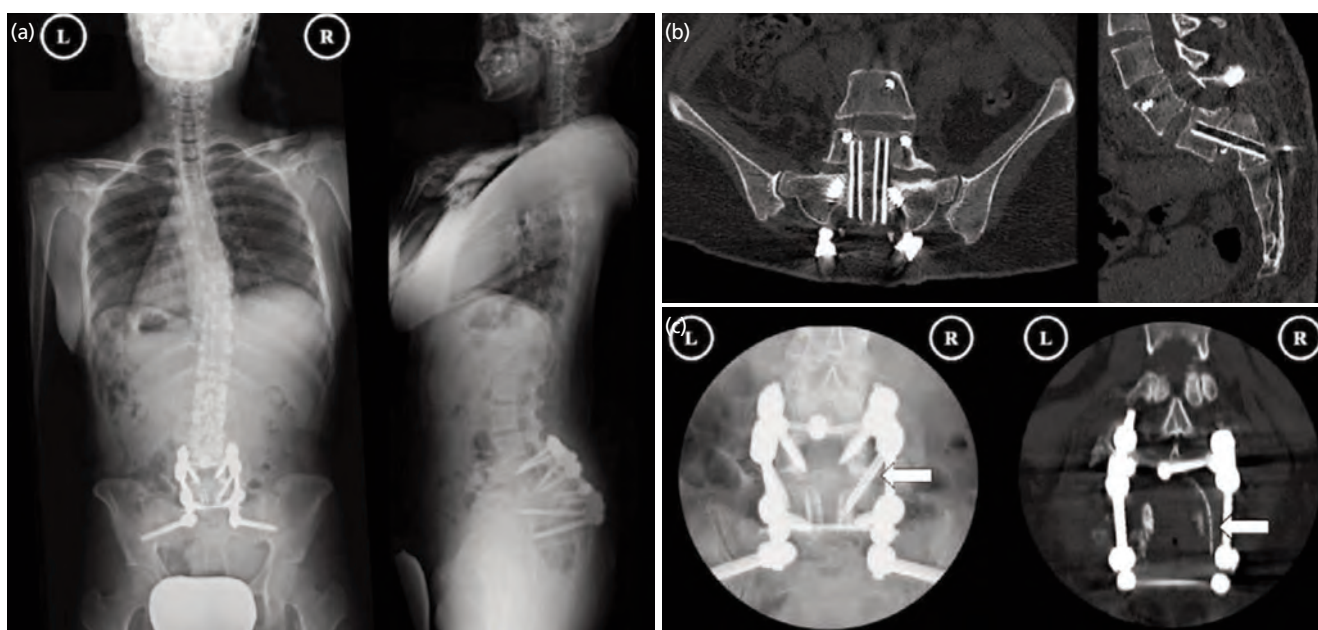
Post-operative radiographic and CT images. (a) Post-operative whole spine radiographs after posterior decompression and instrumented in situ fusion (L4 to S2-ilium). (b) Post-operative CT images showing the fibula grafting penetrating through the L5/S1 disc. (c) Post-operative radiograph and coronal CT image showing the retained drain tube entangled beneath the cross-link junction (white arrow).
